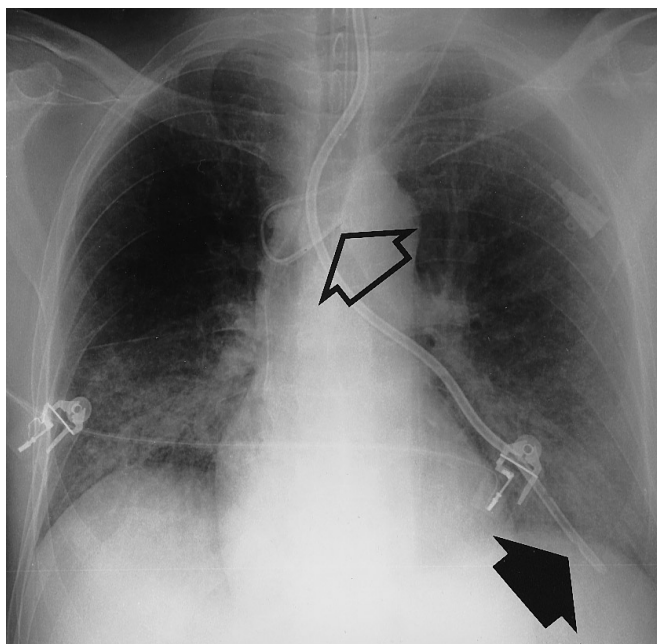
Supine chest radiograph of a 52-year-old intubated and ventilated intensive care patient demonstrates malposition of nasogastric tube with the tube tip in the left tracheobronchial tree (black arrowhead). Despite the distal position of the tube tip, there is no evidence of pneumothorax. Note the curled tip of the central venous catheter inserted over the left jugular vein (open arrowhead)
